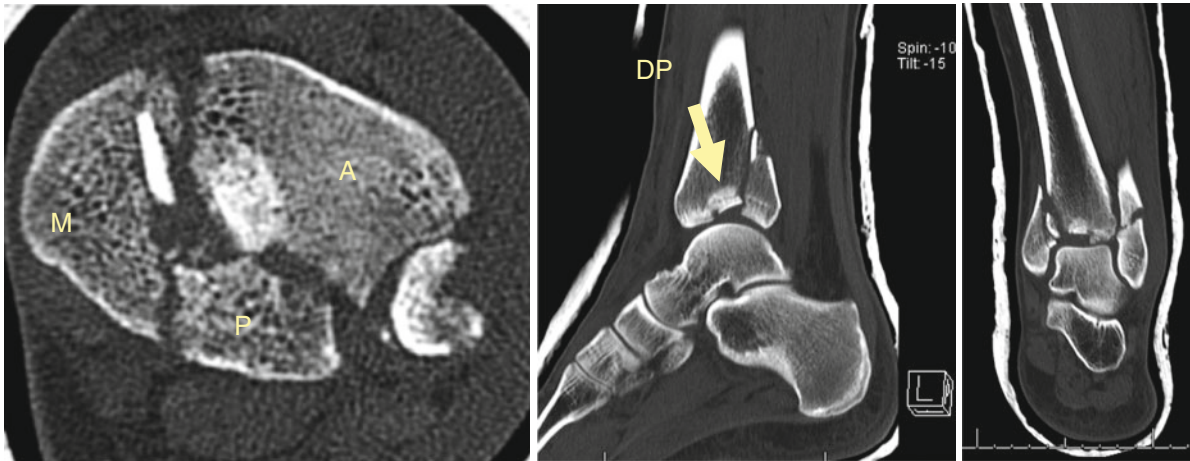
Anterior, posterior, and medial fragments are seen in the CT scan as well as a central articular fragment called a “die-punch” fragment
